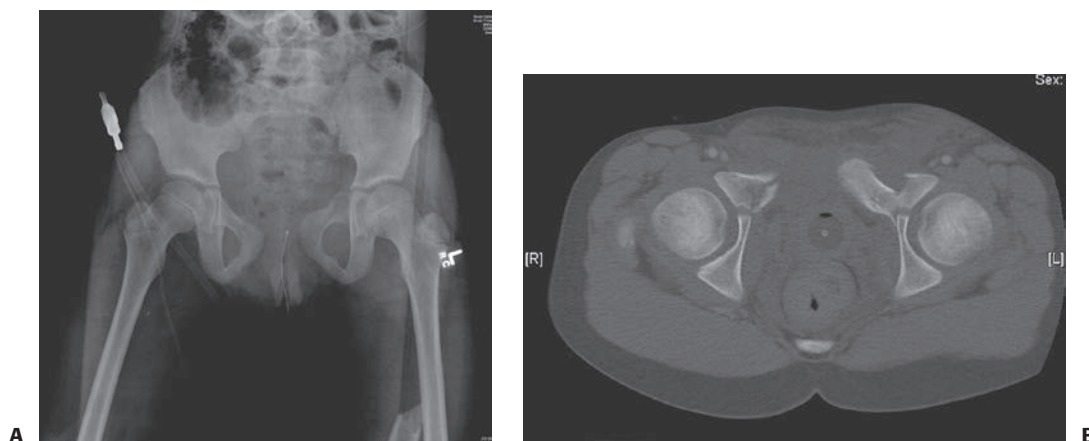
A: Pelvic radiograph showing a pelvic fracture with the left superior rami injury propagating toward the triradiate cartilage. B: CT scan showing the rami fractures propagating into the triradiate cartilage.
